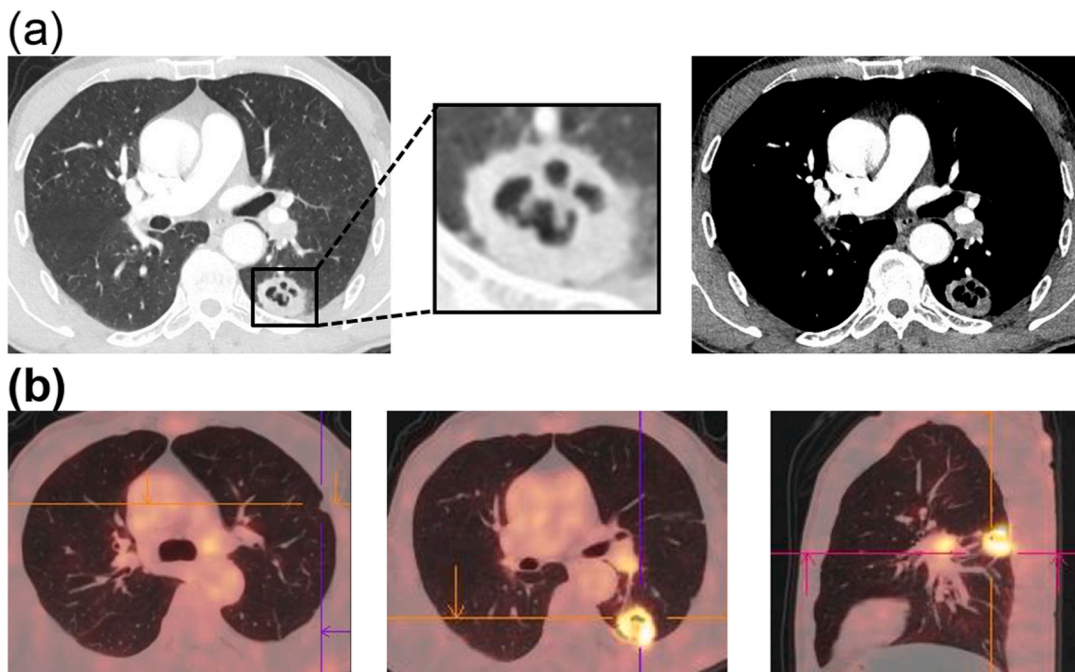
Radiologic findings of the cavitated “Halloween pumpkin”. (A) Chest contrast enhanced CT showed a 32×24 mm thick-wall cavitary mass resembling a “Halloween pumpkin” appearance in the lower lobe of the left lung with enlarged hilar lymph nodes. (B) PET-CT scanning revealed hypermetabolism of 18F-FDG of the cavitary mass and the draining hilar and mediastinum lymph nodes.
